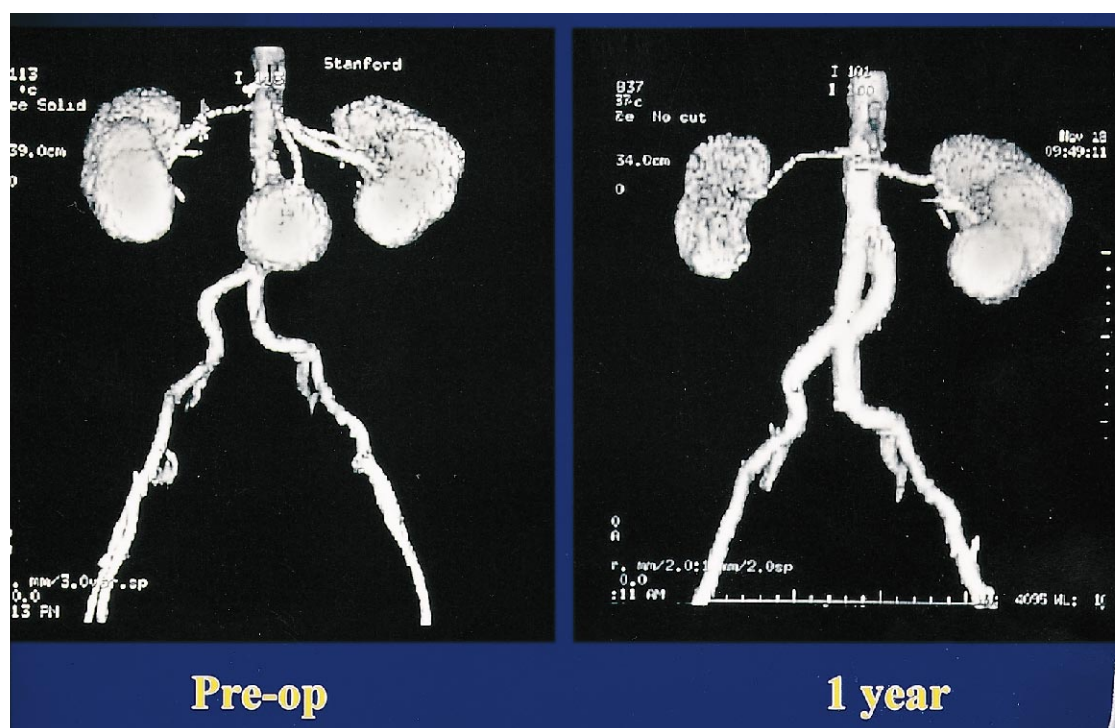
Shaded surface of three-dimensional reconstruction of spiral computed tomographic scan showing: A, a 6.2-cm infrarenal aortic aneurysm in a 65-year-old man; and B, 1 year later, complete exclusion of aneurysm by stent graft. Aneurysm has decreased in size to 5.2 cm (not seen in this image).
